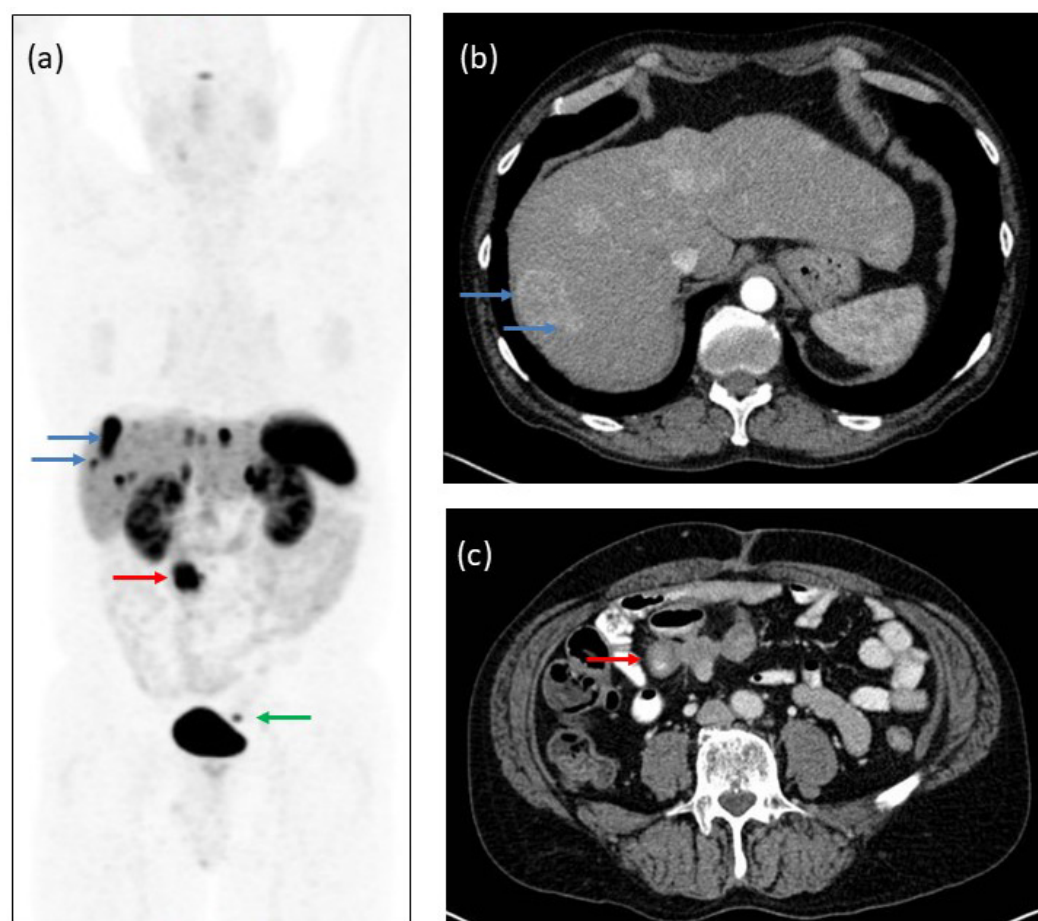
Imaging in a patient with a metastatic small bowel NET. (a) ^{68}Ga DOTATATE PET/CT maximum intensity projection (MIP) image and corresponding (b,c) contrast enhanced CT scan images demonstrating a tracer avid calcified mesenteric mass (red arrows) with multiple bilobar liver metastases (corresponding metastases shown by blue arrows on both imaging modalities) and an unexpected pelvic peritoneal metastasis (the green arrow). The tracer avidity in the pituitary gland, spleen, kidneys and bladder is physiological. CT, computed tomography; PET, positron emission tomography; ^{68}Ga DOTATATE, Gallium- 68 dodecanetetraacetic acid-tyrosine-3-octreotate.
